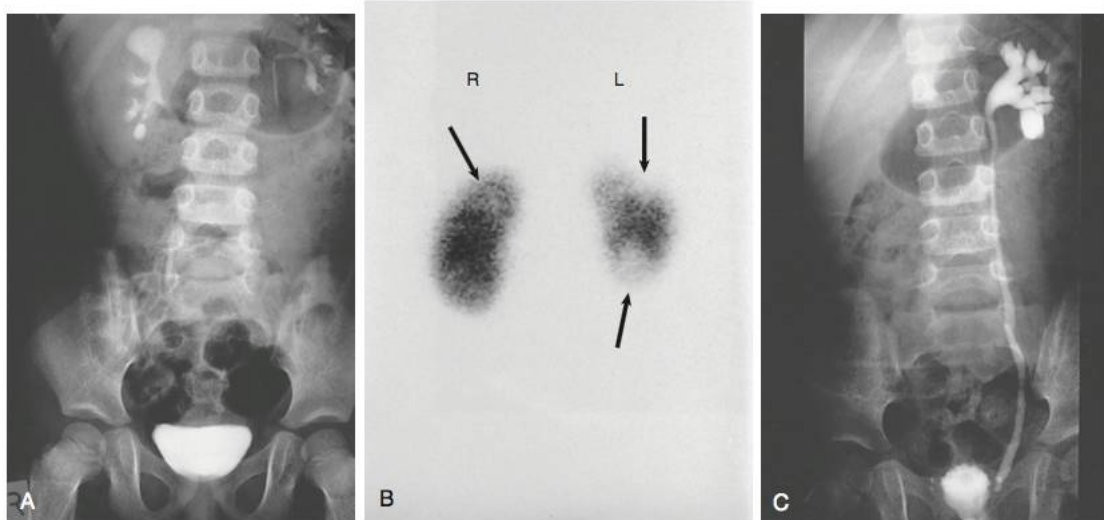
Investigation of reflux nephropathy. Investigation of a 3-year-old child with urinary tract infection. A, Intravenous urogram showing calyceal diverticulum in the upper pole of the right kidney and renal scarring in the upper pole and, probably, the lower pole of the left kidney. B, DMSA scintigraphy (posterior view) demonstrating upper and lower pole scarring (*arrows*) in the left kidney and scarring of the right upper kidney in association with the calyceal diverticulum (*arrowhead*). C, Voiding cystourethrogram showing grade IV vesicoureteral reflux on the left.
